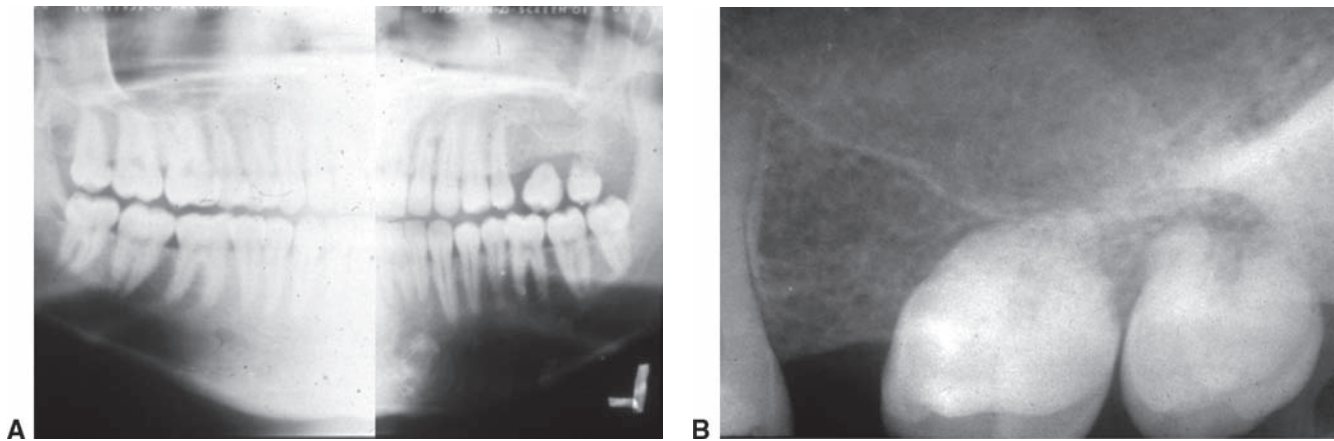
Dentin dysplasia. A. A local area of involvement in the left maxilla is present. The first molar had been lost several years previously due to excessive mobility. B. A periapical radiograph of the same patient as in A shows the almost complete lack of root development associated with the involved molar teeth.
